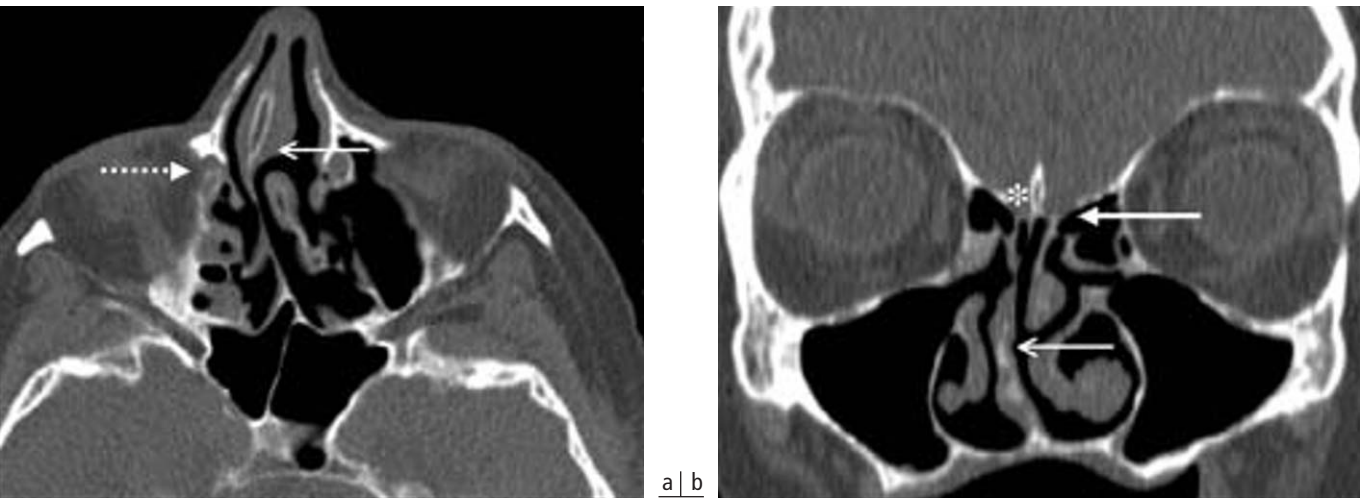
(a) Preoperative axial CT scan showing a marked deviation of the nasal septum (open arrow), adjacent to the opacified lacrimal sac (dotted arrow). (b) Preoperative coronal CT scan. A major meningeal prolapse can be seen below the equator of the orbit (solid arrow), and the marked deviation of the nasal septum (open arrow). The nasal septum is inserted onto the cribriform plate (*) instead of the crista galli. The right middle turbinate is atrophic and distant from the lacrimal duct.
